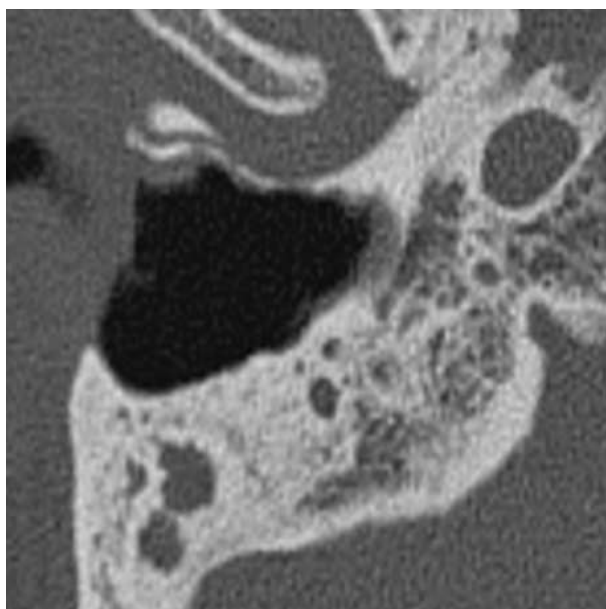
Temporal bone axial CT image showing EACC with erosion of the anterior and posterior walls of the EAC.
